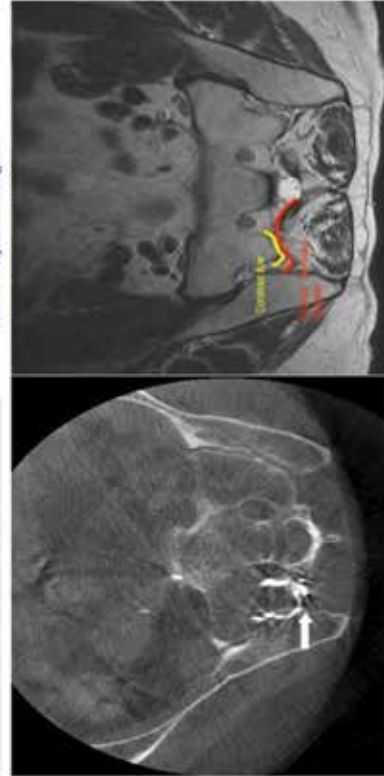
Cone beam CT (left) demonstrating contrast spread in the left sacroiliac joint tracking into the left posterior S1 neuroforamen. The same axial plane on the lumbar spine MRI (right) demonstrating posterior sacroiliac ligament which corresponds to this contrast track.
